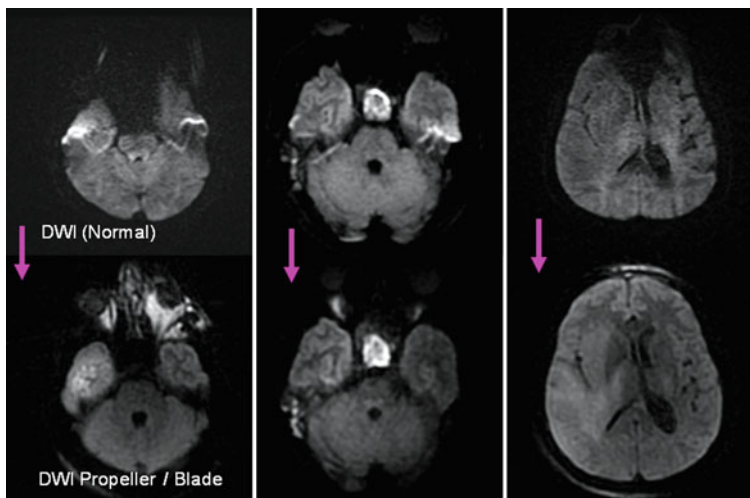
Comparison of EPI DWI and non-EPI DWI (PROPELLER DWI) images shows significant reduction in MR susceptibility artifacts.
